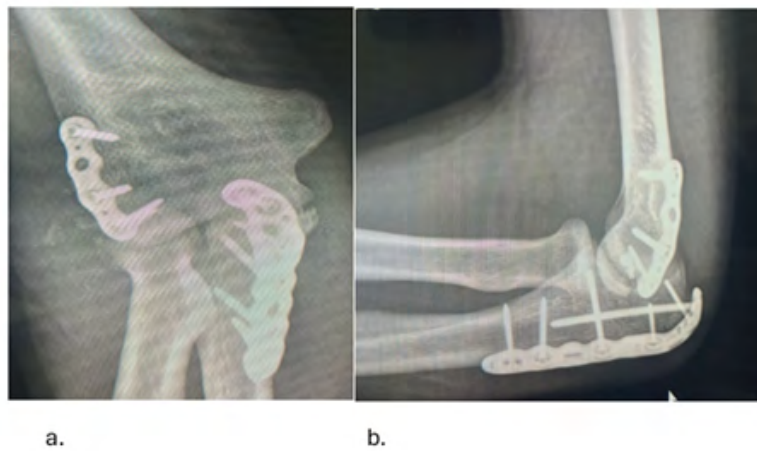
X-ray images one week following the surgery. a. AP X-ray showing the posterior plate at the distal lateral part of the humerus. b. Lateral X-ray demonstrating the distal edge of the plate increasing the safe zone.
